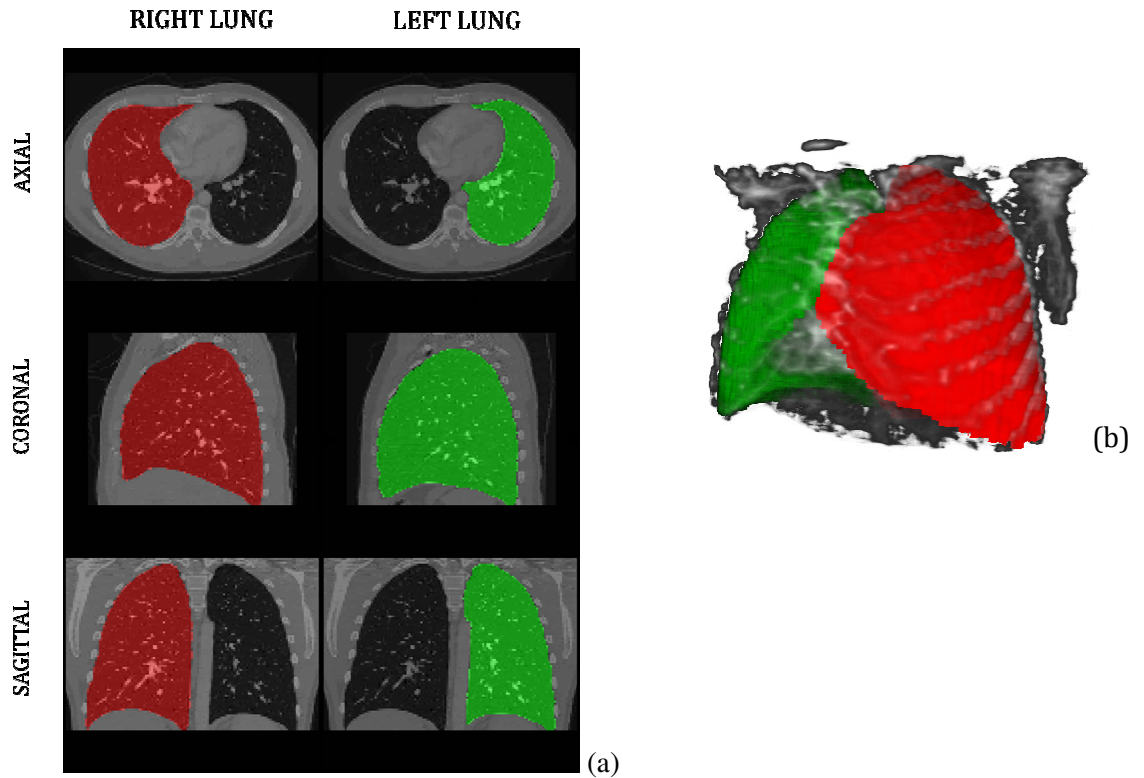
Overlay between CT binary masks and CT scan of a reference lung in (a) axial, coronal and sagittal perspectives; and a three-dimensional representation. Right lung is in red and left lung in green.
